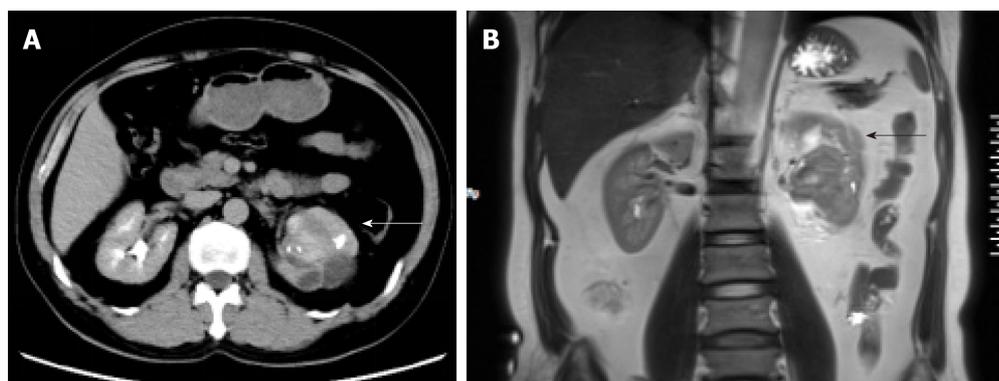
Imaging examination of our case of renal organ-associated pseudosarcomatous myofibroblastic proliferation. A: Computed tomography showed a heterogeneous mass (indicated with arrows) of 6 cm in diameter at the left pyeloureteral junction; B: Magnetic resonance imaging showed that the left renal pelvis was occupied by a cystic and solid mass (indicated with arrows) with calcification or ossification.
